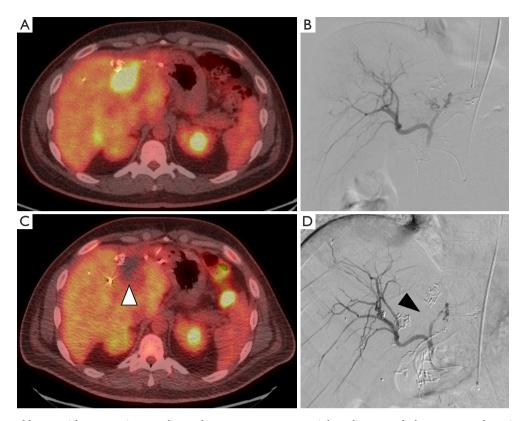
49-year-old man with metastatic ascending colon cancer, status post right colectomy, cholecystectomy, hepatic arterial infusion pump placement and hepatic resection, with progressing bilobar liver metastases after two lines of chemotherapy and intrahepatic floxuridine. (A) Baseline PET/CT shows one of the FDG-avid hepatic tumors in segment 4. (B) Proper hepatic arteriogram before the 1st mitomycin-C infusion demonstrates the hepatic arterial anatomy. Due to the extent of disease, infusions were performed from the proper hepatic artery. (C) Follow-up PET/CT after 8 infusion sessions (10 months after the 1st infusion) shows photopenic defect in segment 4 (white arrowhead), compatible with complete metabolic response. (D) Proper hepatic arteriogram after the 8th infusion shows diffusely abnormal appearance of the intrahepatic arterial branches, with multifocal stenoses, vessel contour irregularities, pruning of the distal branches and interval occlusion of the segment 4 branch (black arrowhead). Due to the angiographic findings and rising bilirubin levels, the infusions were discontinued. PET/CT, positron emission tomography/computed tomography; FDG, fluorodeoxyglucose.
